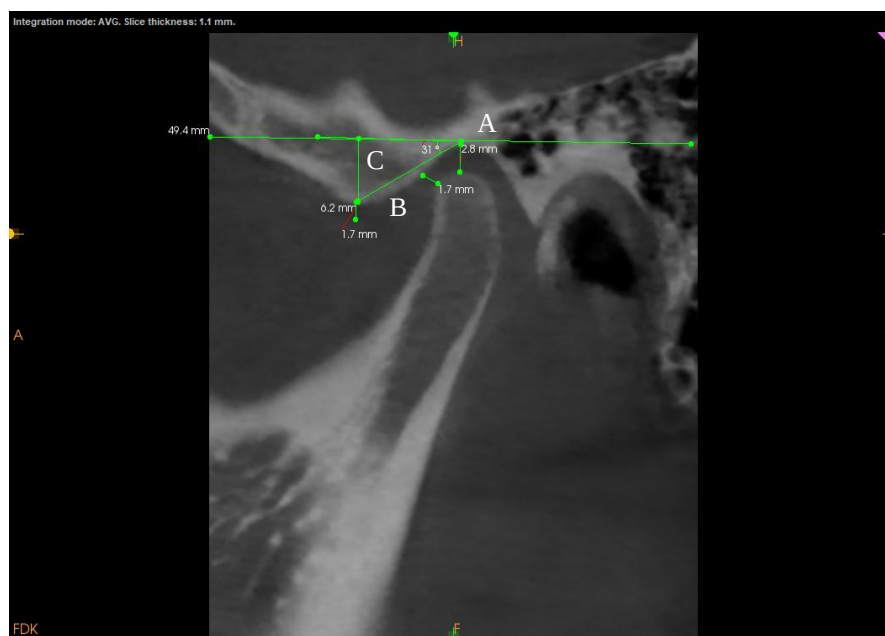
Condylar guidance obtained for a participant using CBCT. A: FH plane (Frankfort horizontal plane), B: Line from most superior to most inferior point of the curvature of glenoid fossa, C: Sagittal condylar guidance angle; angle made by intersection of line A and B.
